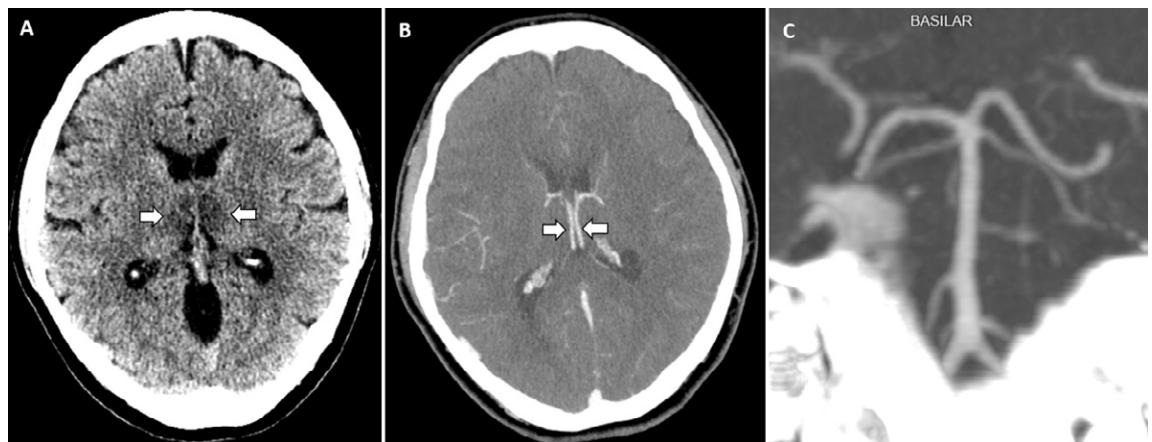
A*, Image from noncontrast head CT demonstrates symmetric hypoattenuation within the bilateral medial thalami (arrows). *B*, Axial CT venogram demonstrates patency of the cerebral venous vasculature, including the internal cerebral veins (arrows). *C*, Coronal reformat of aCT angiogram demonstrates normal appearance of the basilar artery and proximal posterior cerebral arteries.
